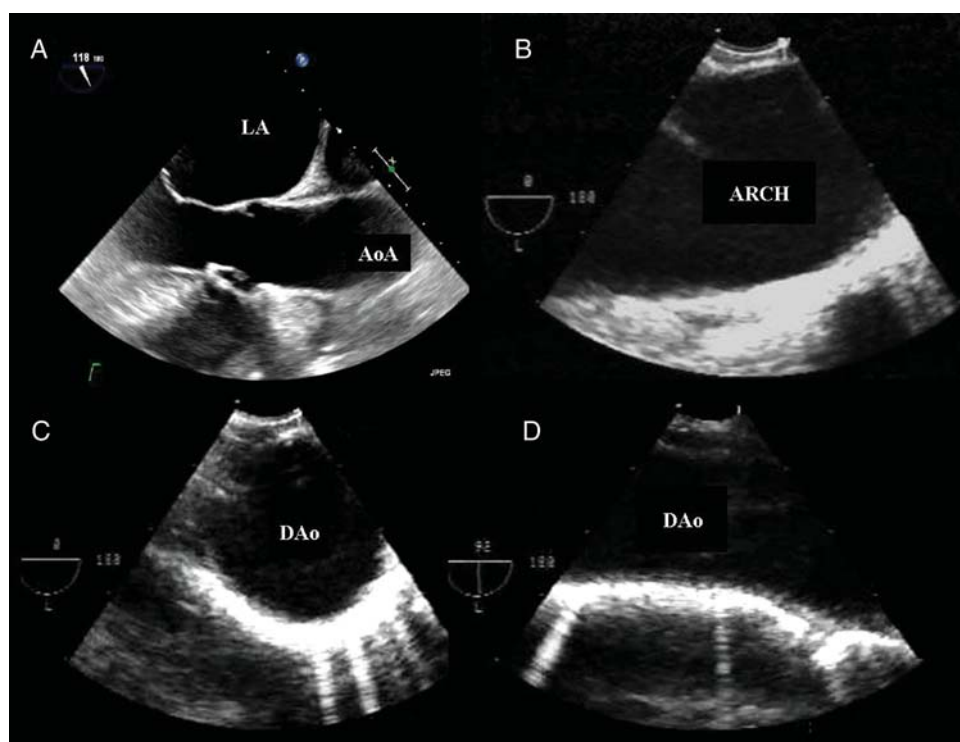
Transoesophageal echocardiography. (A) Ascending aorta in long-axis view at 120°. (B) Aortic arch in transverse view. (C) Descending aorta visualized by transverse view. (D) Descending aorta visualized by longitudinal view.
